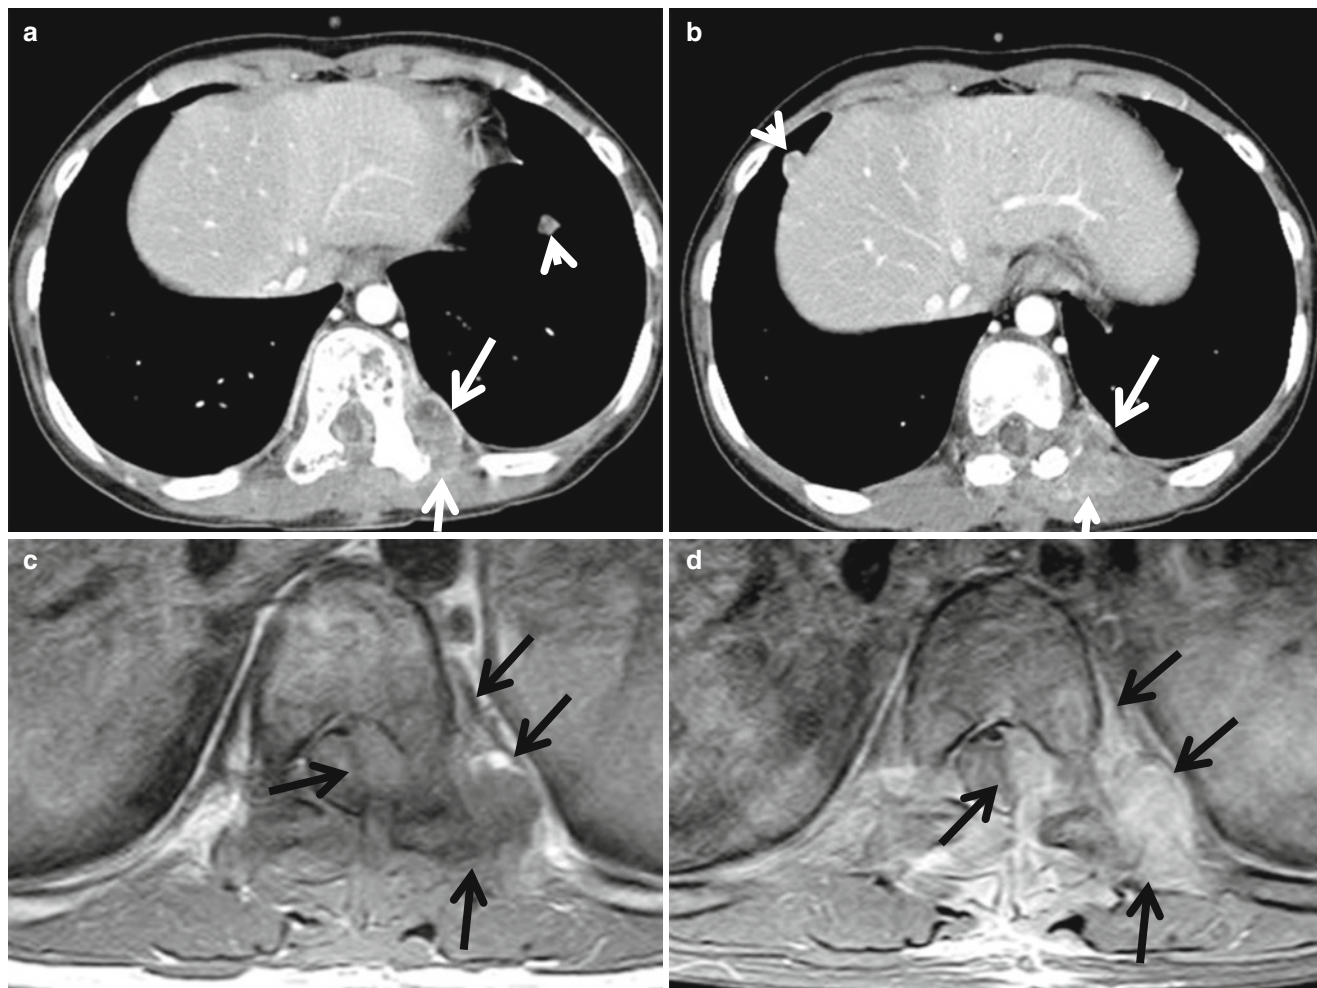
PNET (Askin) tumor with local invasion and metastasis in a 5-year-old boy. (a, b) Contrast-enhanced CT shows a heterogeneous mass (arrows) located posteriorly in the left chest wall with extension to the back muscle and spinal canal, as well as multiple pulmonary
